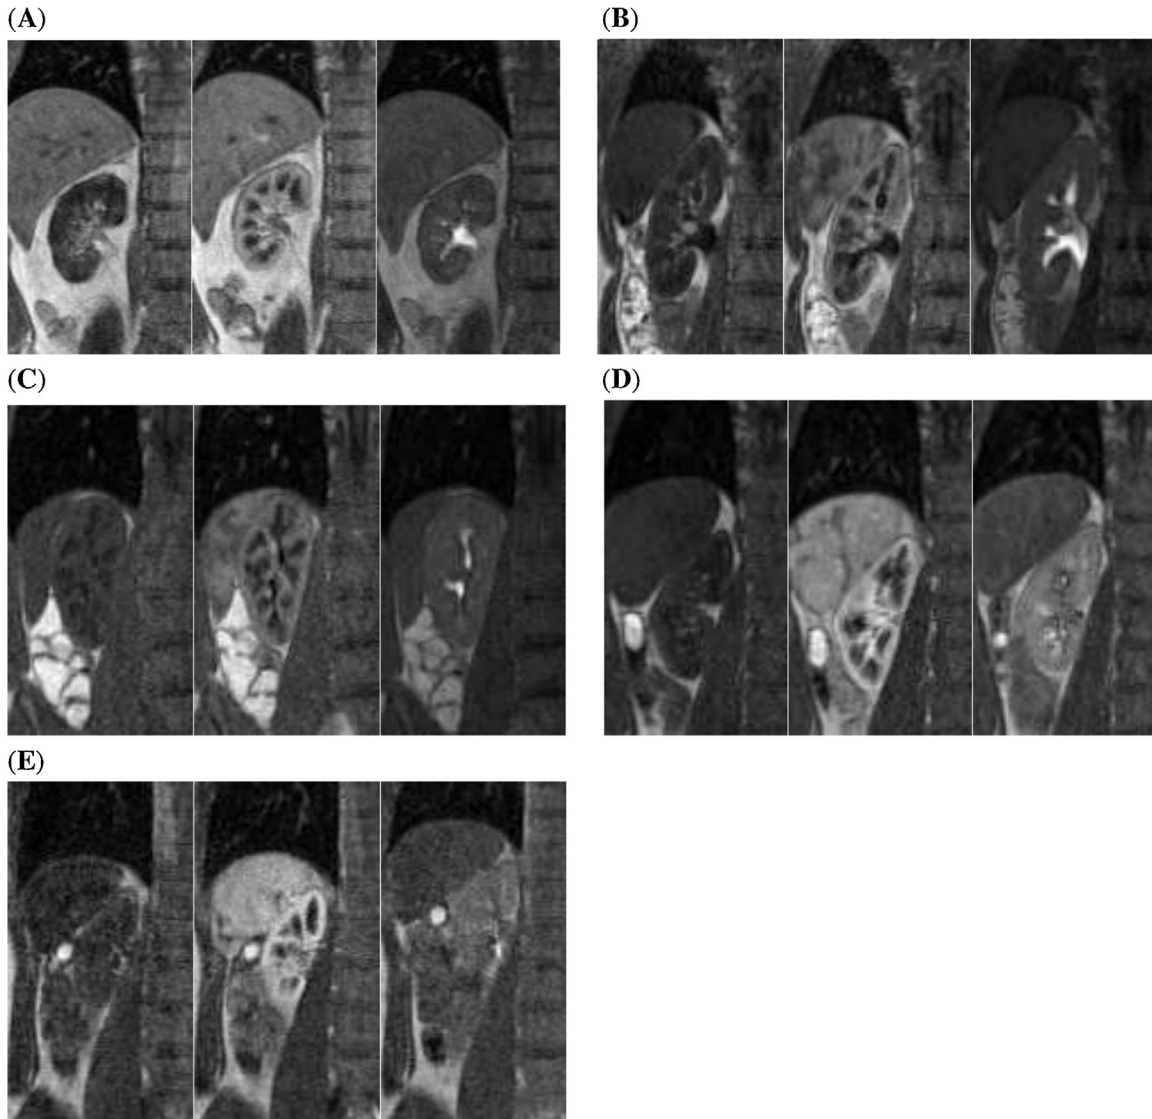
Unprocessed DCE-MRI time sequences before contrast (left image), at maximal contrast enhancement, cortical phase (middle image) and late-contrast, pelvic phase (right image) for the five subjects included in the study (A–E).
